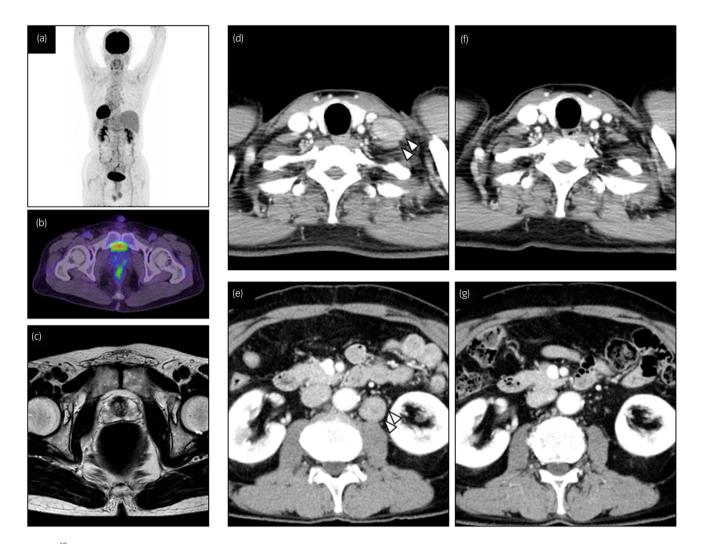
¹⁸F-Fluorodeoxyglucose positron emission tomography/CT did not show abnormal uptake in (a) other organs and (b) the prostate on a whole-body scan. (c) Prostate MRI did not show a significant abnormality. CT images showed recurrences in (d) the supraclavicular and (e) para-aortic nodes 3 months after the resection of the primary lesion. (g) A follow-up CT showed a significant reduction of the lesions after an 18-month CAB therapy.
